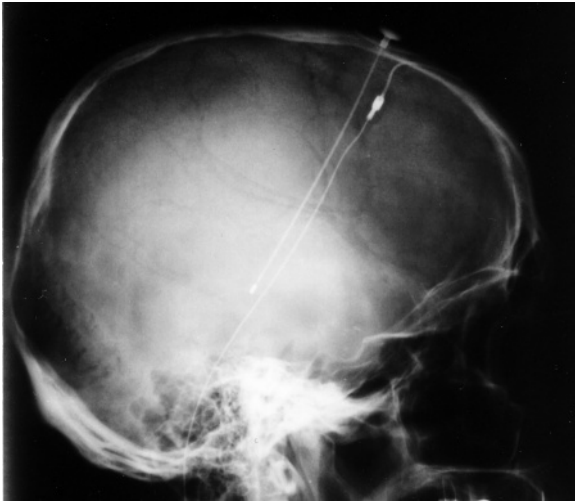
Skull radiograph showing a deep brain stimulation apparatus in place.
